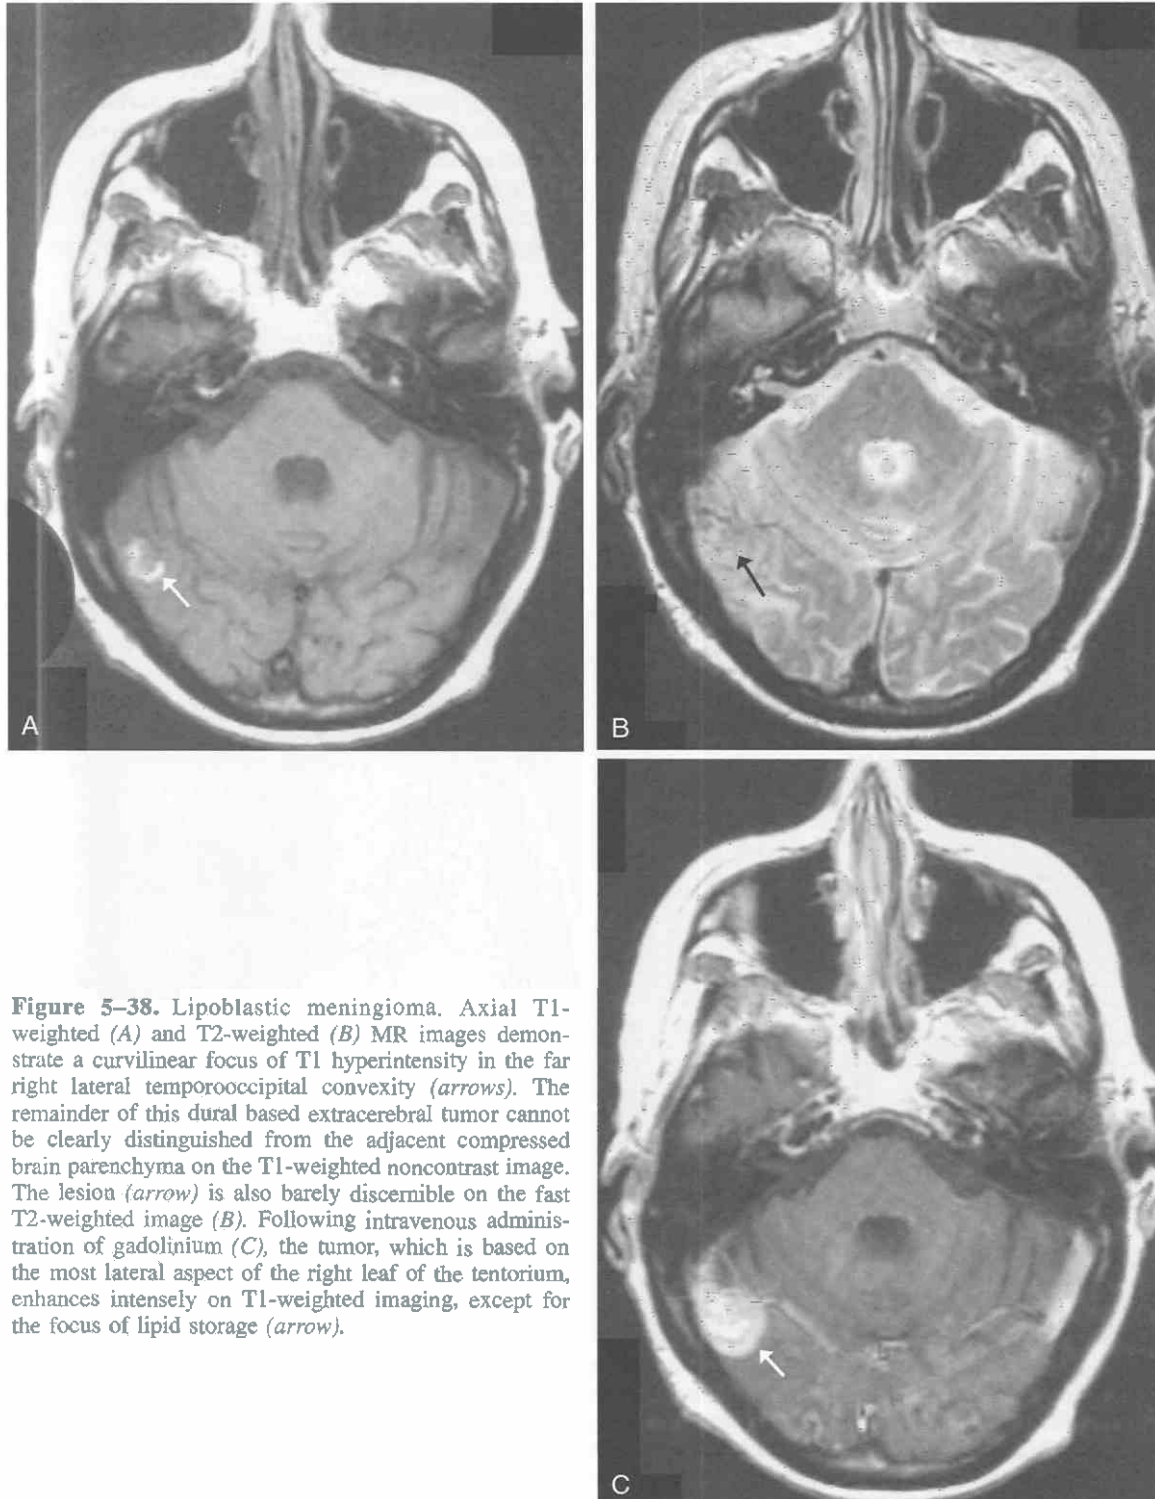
Lipoblastic meningioma. Axial T1-weighted (A) and T2-weighted (B) MR images demonstrate a curvilinear focus of T1 hyperintensity in the far right lateral temporooccipital convexity (arrows). The remainder of this dural based extracerebral tumor cannot be clearly distinguished from the adjacent compressed brain parenchyma on the T1-weighted noncontrast image. The lesion (arrow) is also barely discernible on the fast T2-weighted image (B). Following intravenous administration of gadolinium (C), the tumor, which is based on the most lateral aspect of the right leaf of the tentorium, enhances intensely on T1-weighted imaging, except for the focus of lipid storage (arrow).
